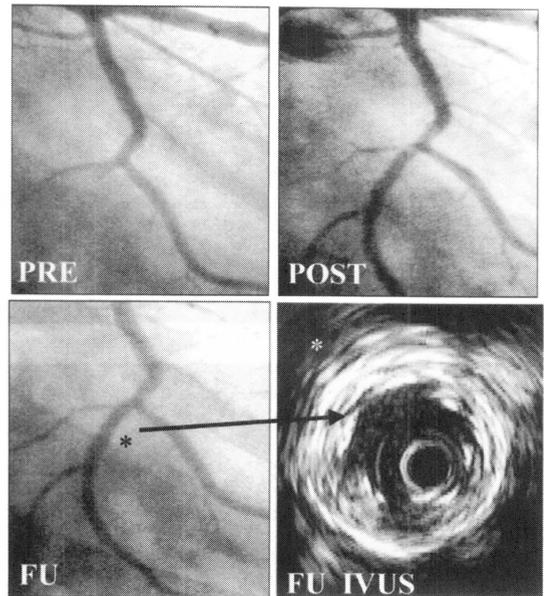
A chronically occluded left circumflex due to in-stent restenosis (PRE) was treated with a sirolimus eluting stent (POST). Follow-up (FU) angiogram showed no restenosis; intravascular ultrasound (IVUS) revealed no neointimal hyperplasia with the clear appearance of double stent struts. * indicates the position of the IVUS catheter.
